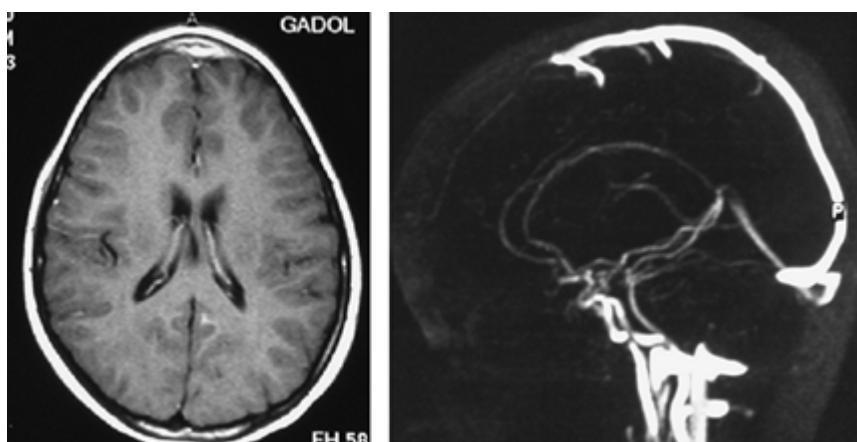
Gadolinium-enhanced, T1-weighted MRI (*left*) and MR angiography (*right*) showing epidural empyema and occlusion of anterior half of superior sagittal sinus in patient presenting with tonic-clonic generalized status epilepticus.
